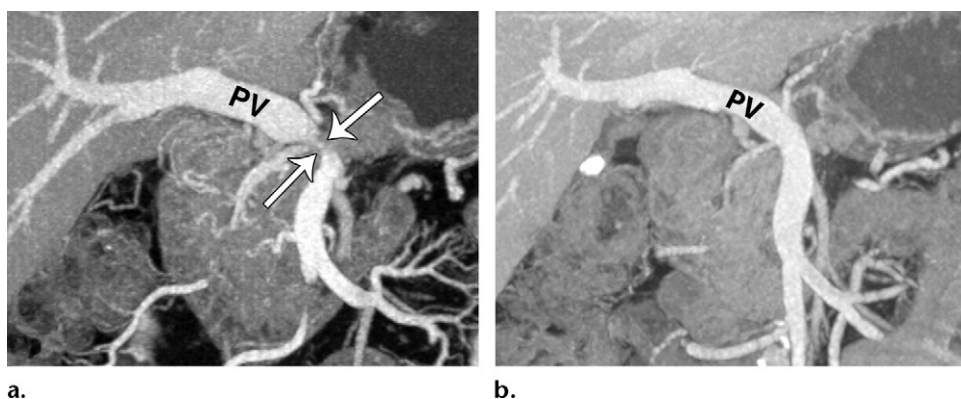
PDAC in the pancreatic head in a 71-year-old man. *PV* = portal vein. (a) Coronal contrast-enhanced CT maximum intensity projection image shows a mass in the pancreatic head, with nearly complete occlusion (arrows) of the portal vein. The patient received neoadjuvant chemoradiation therapy for 5 months. (b) Coronal contrast-enhanced maximum intensity projection CT image obtained after the patient completed the preoperative treatment shows that the portal vein has regained its normal caliber. The patient underwent successful resection, with negative resection margins.
